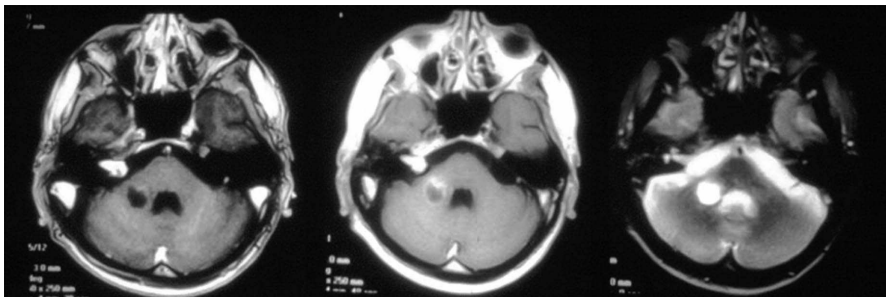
Follow-up MR images of a patient who was treated for a right sided acoustic tumor using LINAC radiosurgery at an outside facility. The axial images show a radiation effect in the middle cerebellar peduncle which is completely outside the TV (tumor). This patient developed profound ipsilateral limb ataxia 6 months after undergoing LINAC radiosurgery.
